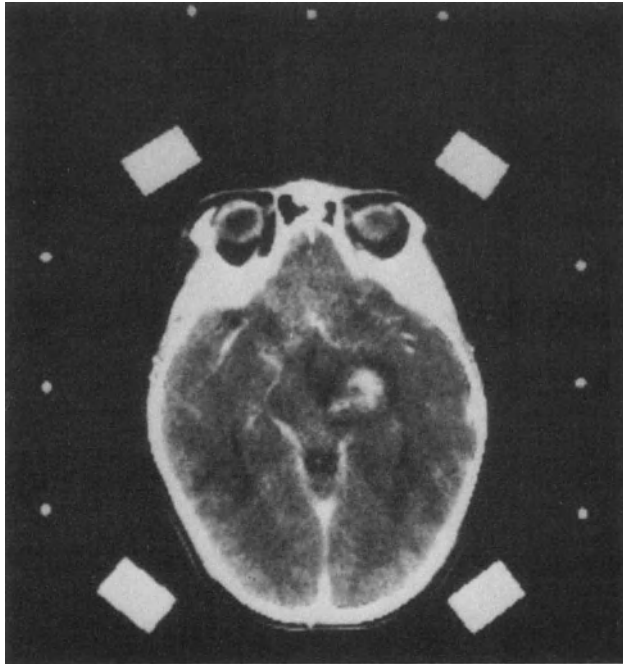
Stereotactic CT image demonstrating an absence of artifact when molybdenum disulfide vertical supports are used.
